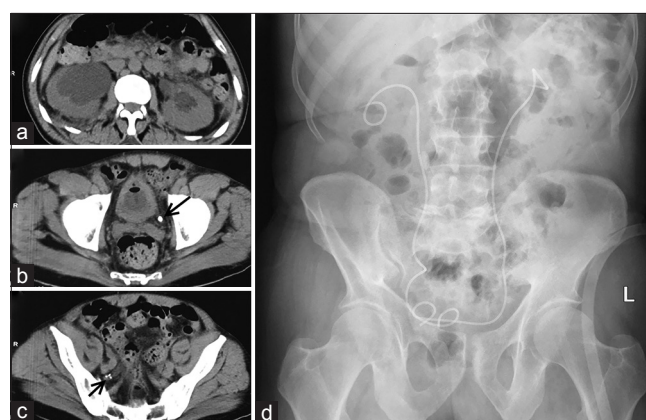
Emergency noncontrast computed tomography (kidneys, ureters, and bladder) showing bilateral hydronephrosis (a) and renal calculi in the both distal ureters (b and c; arrows) suggesting acute ureteric obstruction. Double J stenting was done in both ureters which can be seen in the postintervention X-ray image (d)
